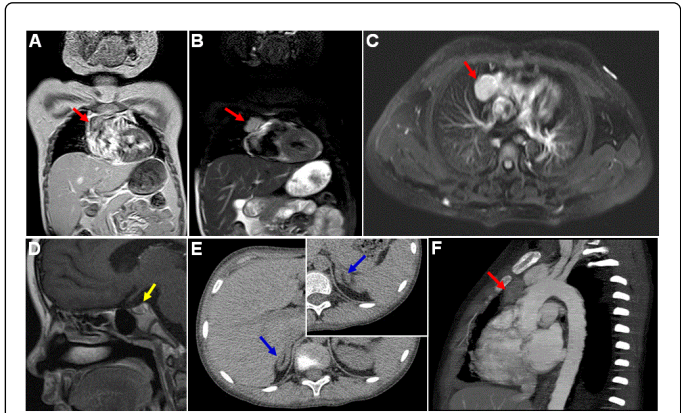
Images from a 7-year old boy with Cushing's syndrome due to a thymic atypical carcinoid tumor. A,B,C: MRI of the mediastinal mass (red arrows). D: MRI of the normal pituitary in the parasellar region (yellow arrow). E and insert: CT imaging of the bilateral adrenal cortical hyperplasia (blue arrows). F: CT imaging of the mediastinal mass which was overlooked initially (red arrow).
